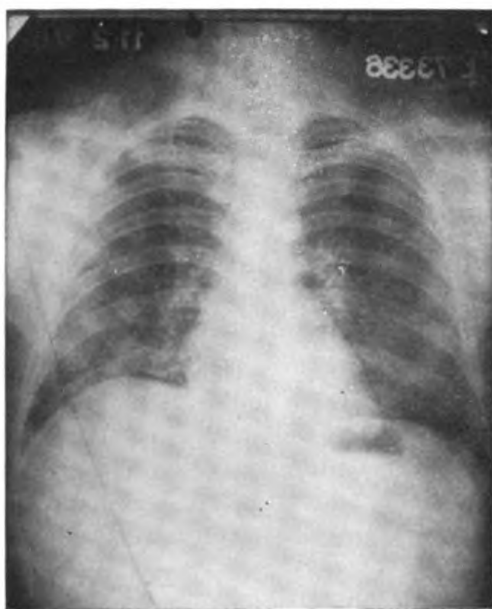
Case 1. Final chest x-ray following therapy.
